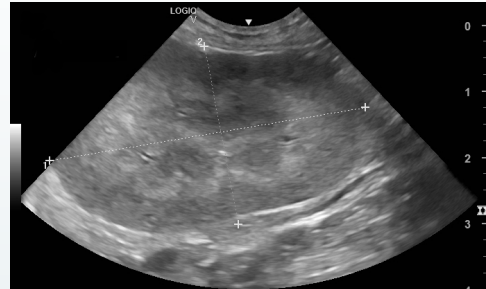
Ultrasound of left kidney on the day of presentation. Notice the hyperechoic inner cortex and medulla.
